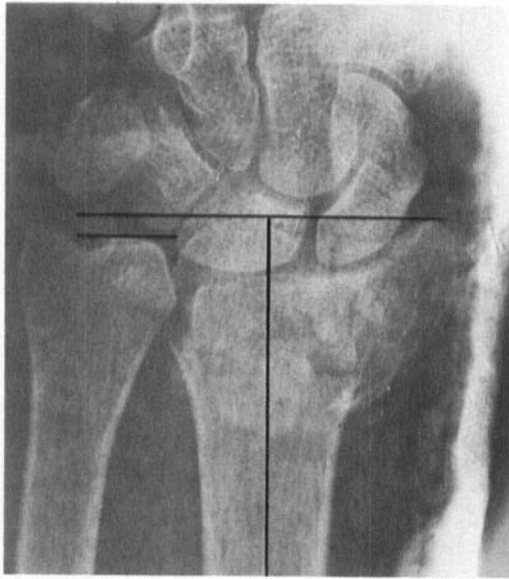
The interval X-ray check-up after 12 days reveals an unacceptable redislocation of this Frykman type 8 Colles' fracture.
